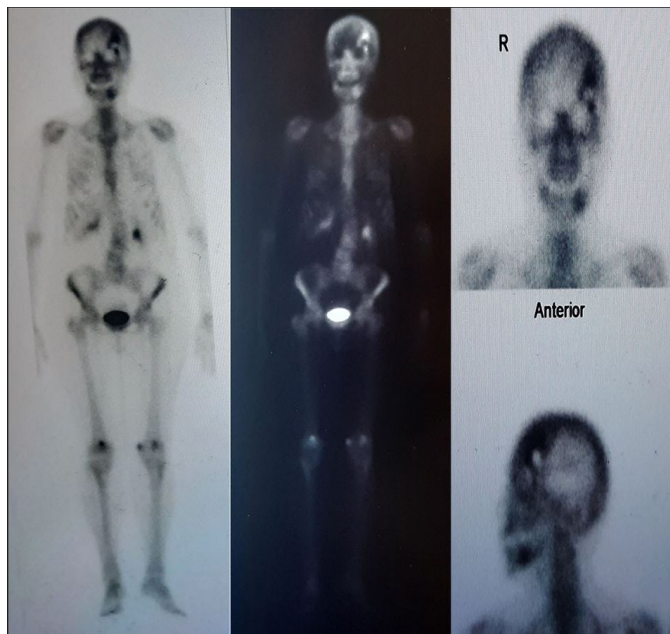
Bone scintigraphy revealing a sole bone metastasis in the left frontal bone, above the left orbital cavity.
